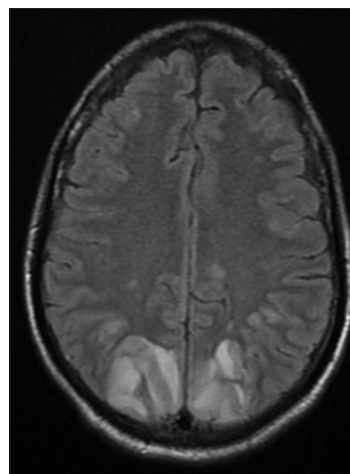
MRI; bilateral frontoparietal occipital T2 hyperintensities (original)
